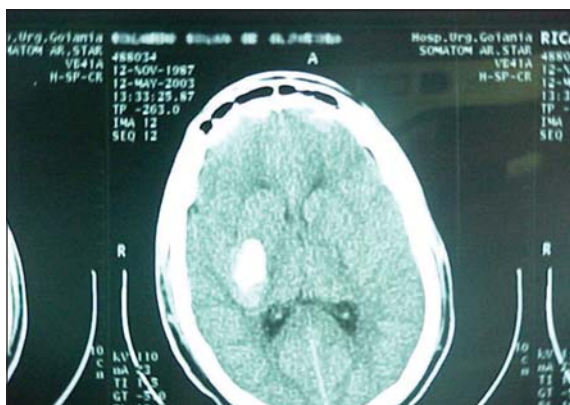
CT of the cranium showing periventricular intraparenchymal hemorrhaging at the left
